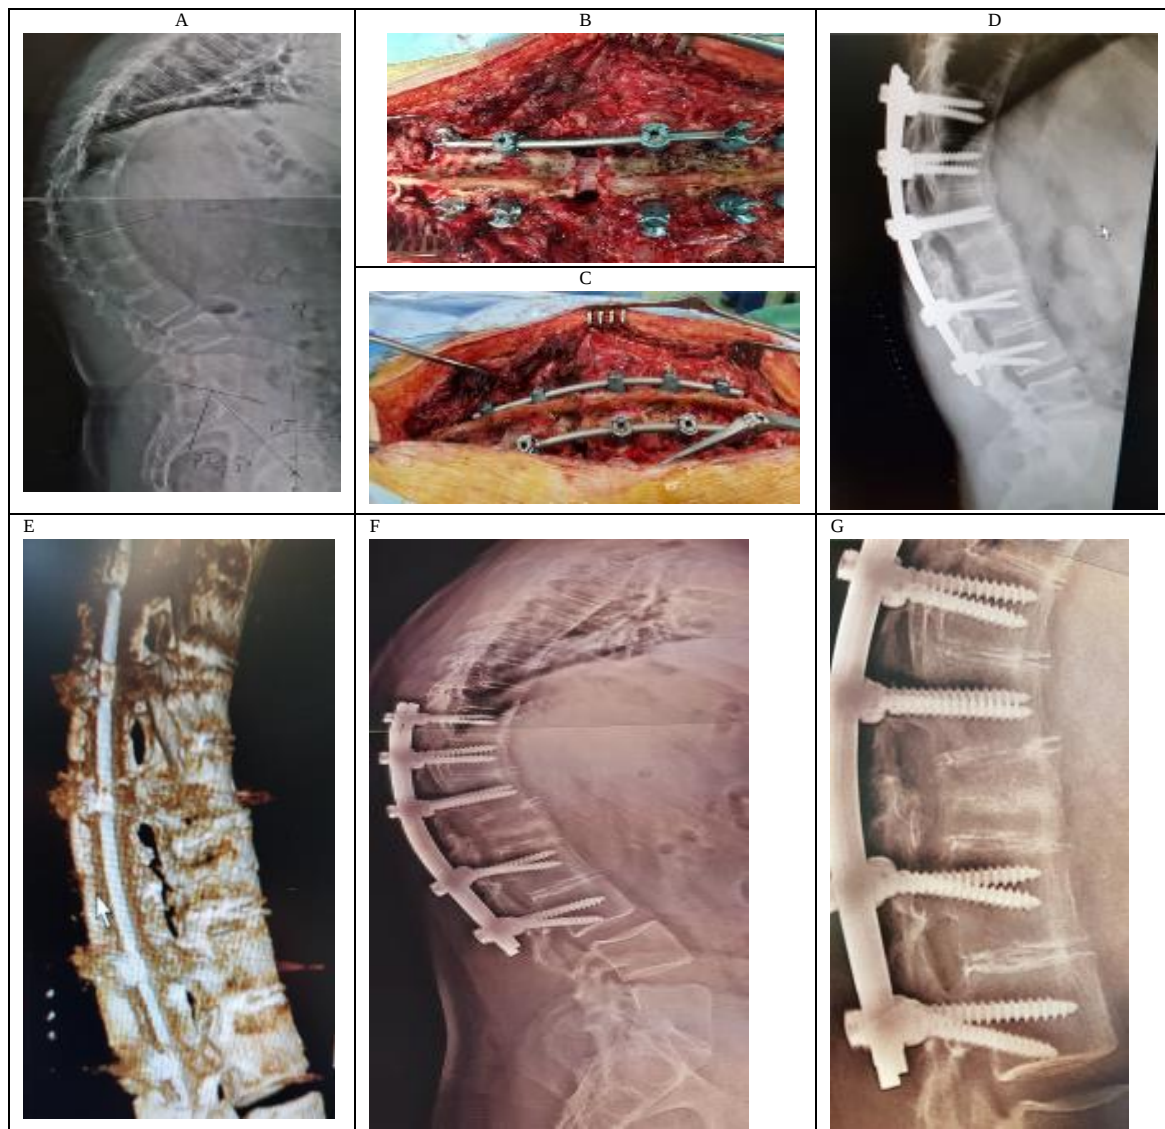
Representative case of ankylosing spondylitis (AS) treated with the modified compact-contact pedicle subtraction osteotomy (PSO) technique. A) Preoperative standing radiograph of a 39-year-old man with AS and fixed sagittal plane deformity (FSPD); B, C) Intraoperative photographs of the L1 osteotomy showing direct contact between the preserved laminae and spinous processes after closure of the osteotomy; D, E) Standing radiograph and computed tomography (CT) images obtained six months postoperatively demonstrating satisfactory bony fusion at the osteotomy site; F, G) Standing anteroposterior (AP) and lateral radiographs obtained three years after surgery showing maintained sagittal alignment, stable instrumentation, and solid fusion across the osteotomy site
